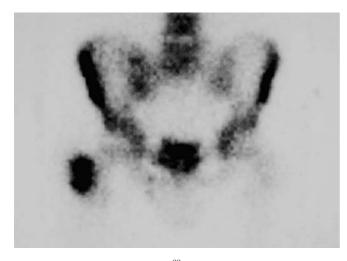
Bone scintigraphy with ^{99m}Tc MDP exhibiting increased radioisotope uptake at the right sacroiliac joint, the right trochanteric area and ischial tuberocity
